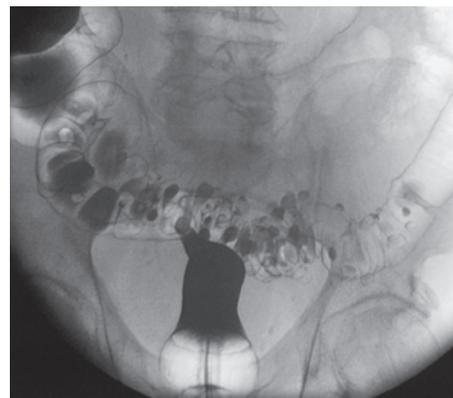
Sigmoid diverticulosis, visible on radiographs with contrast enema.
